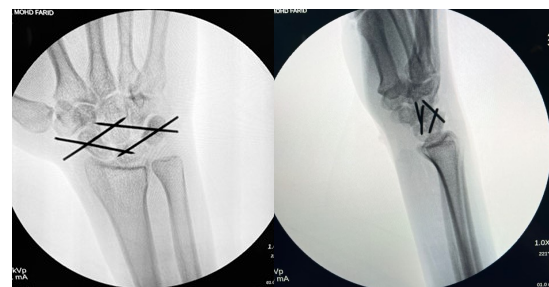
PA and lateral post-operative radiographs.
